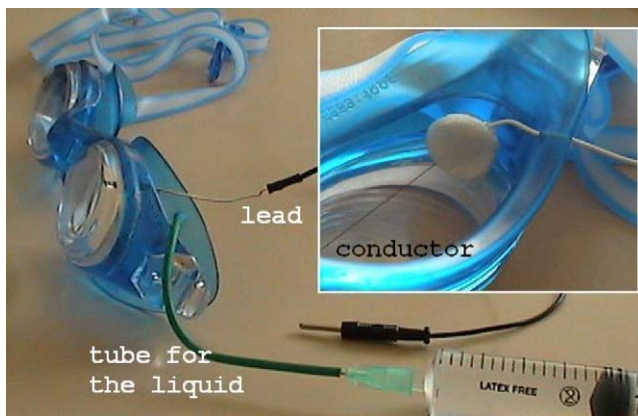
Prototype CT electrode. The glasses are equipped with a thin linear recording conductor (visible in the inserted image), its lead and a small tube for the insertion of the liquid.
